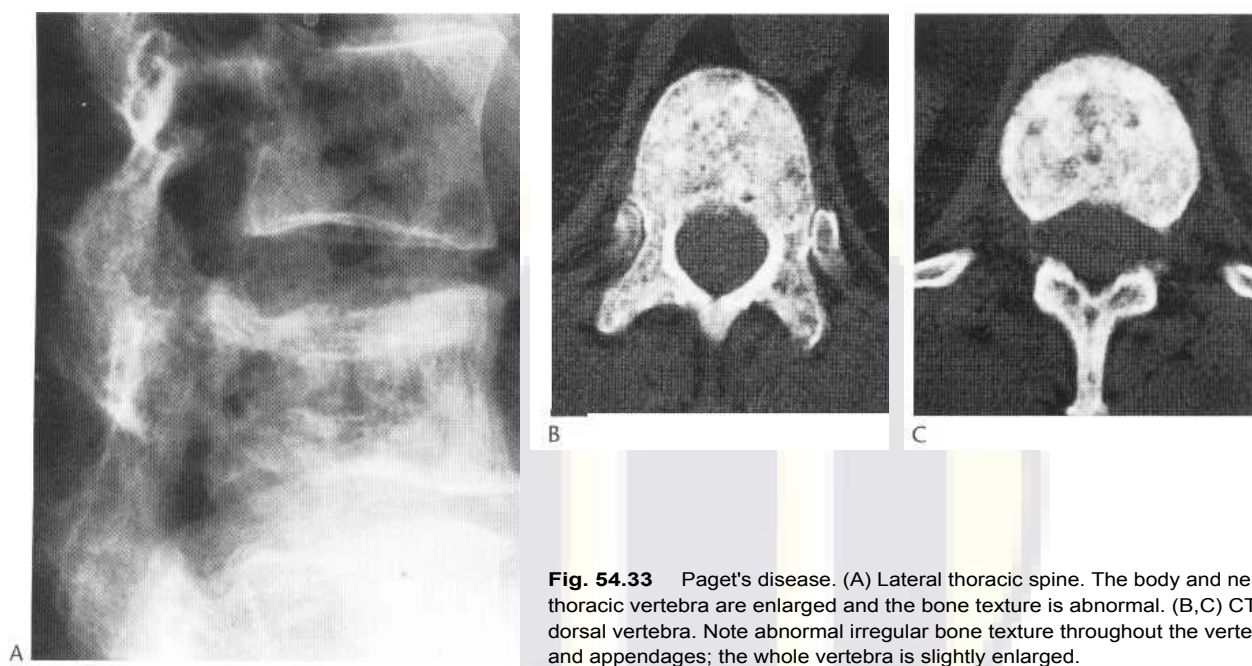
Paget's disease. (A) Lateral thoracic spine. The body and neural arch of the twelfth thoracic vertebra are enlarged and the bone texture is abnormal. (B,C) CT axial sections, lower dorsal vertebra. Note abnormal irregular bone texture throughout the vertebral body, neural arch and appendages; the whole vertebra is slightly enlarged.
